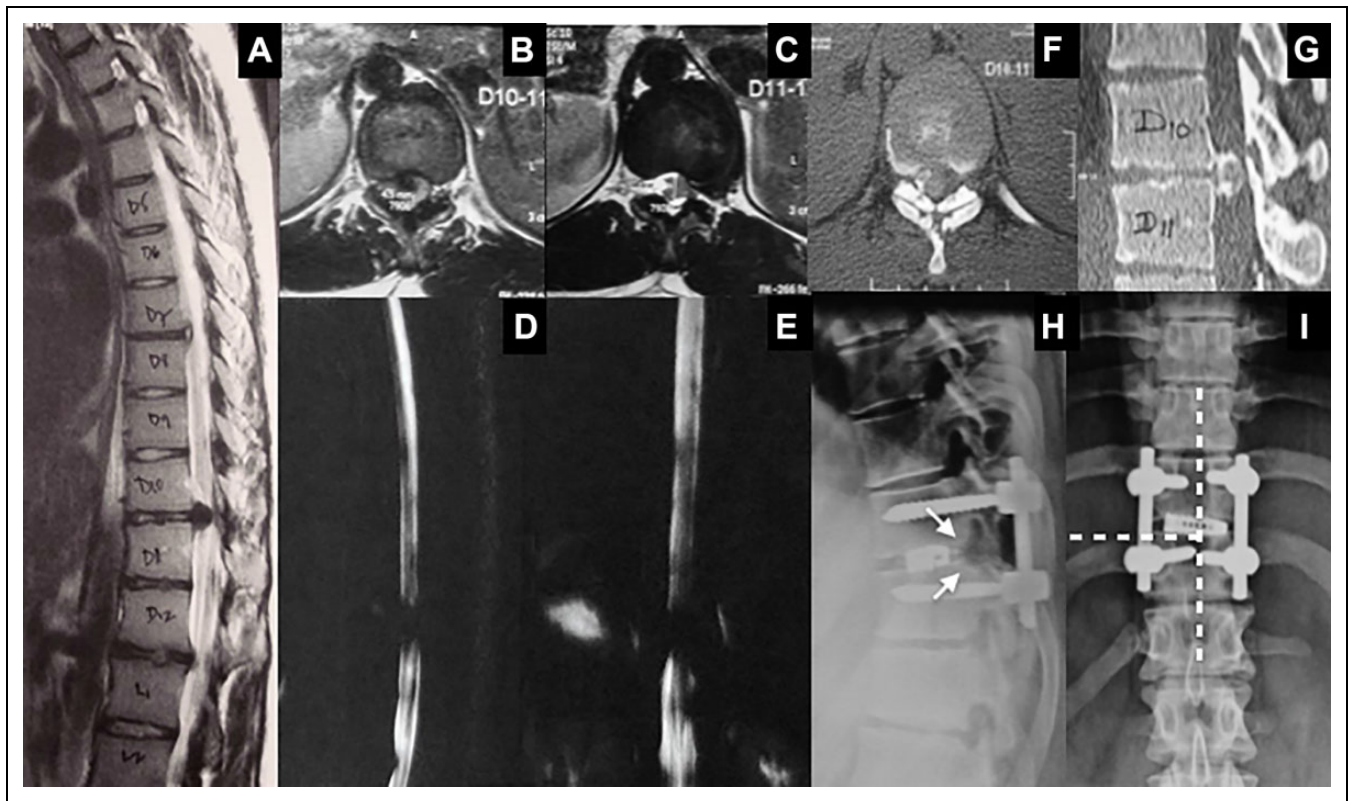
Magnetic resonance imaging (MRI): T2 sagittal (A), T1 axial (B), T2 axial (C), and sagittal and coronal MR myelogram (D, E) showing central extruded disc with paracentral encroachment and a canal occupancy >50% with complete myeloblock. Axial computed tomography (CT) scan (F) and sagittal CT scan (G) showing calcified disc. Postoperative lateral (H) and anteroposterior (I) radiographs showing single segment pedicle screw construct with interbody cage. Bilateral facetectomy and complete laminectomy was needed after a T incision exposure. The dotted line shows the overlay of the exposure. The arrows show the blunting of the end-plate margins, which is the oblique osteotomy cutting of the margin of the end-plate.
